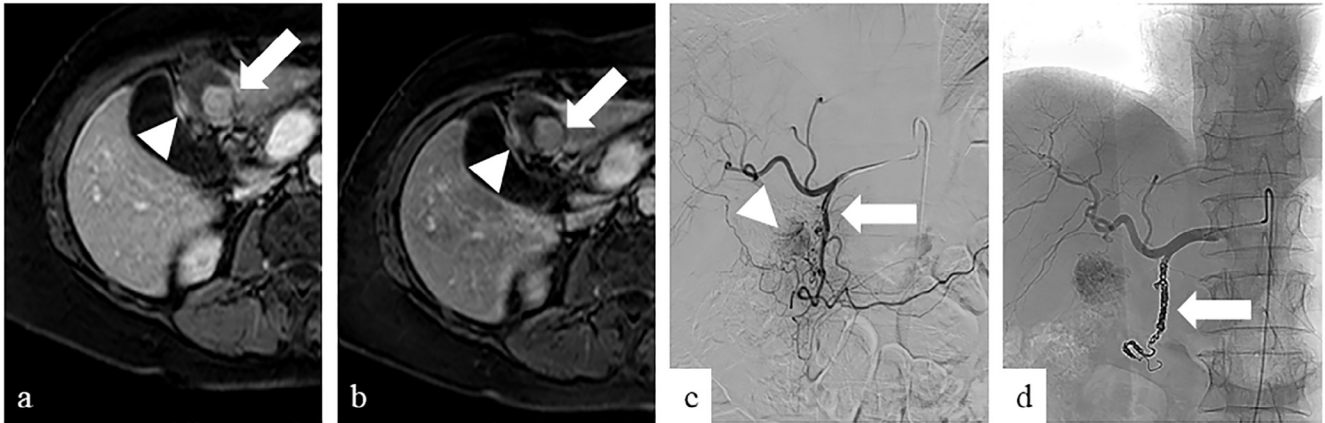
Four weeks after transarterial chemoembolization treatment #2, magnetic resonance imaging was performed as part of our institutional standard-of-care to monitor for residual tumor viability. (a) Fat saturated T1 post-contrast sequence magnetic resonance imaging shows continued evidence of 2.2 cm (arrow) and 1.0 cm (arrowhead) arterially enhancing lesions (previously 2.3 cm and 1.1 cm) with washout on (b) delayed phase fat saturated T1 sequence. The patient was brought back to the interventional suite for additional treatment. (c) Digital subtraction angiography via the gastroduodenal artery demonstrates collateralization from the gastroduodenal artery (arrow) to the inferomedial portion of the tumor bed (arrowhead). (d) Angiography via the common hepatic artery shows successful coil embolization of the gastroduodenal artery (arrow) and no tumor enhancement.
